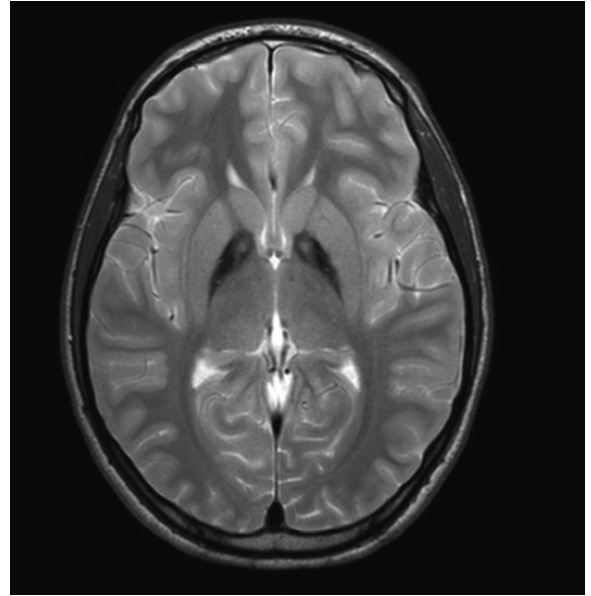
MRI of a patient with PKAN. Axial T2-weighted imaging of the globus pallidus demonstrating a central pallidal hyperintense signal surrounded by hypointense signal (“eye of the tiger”).
